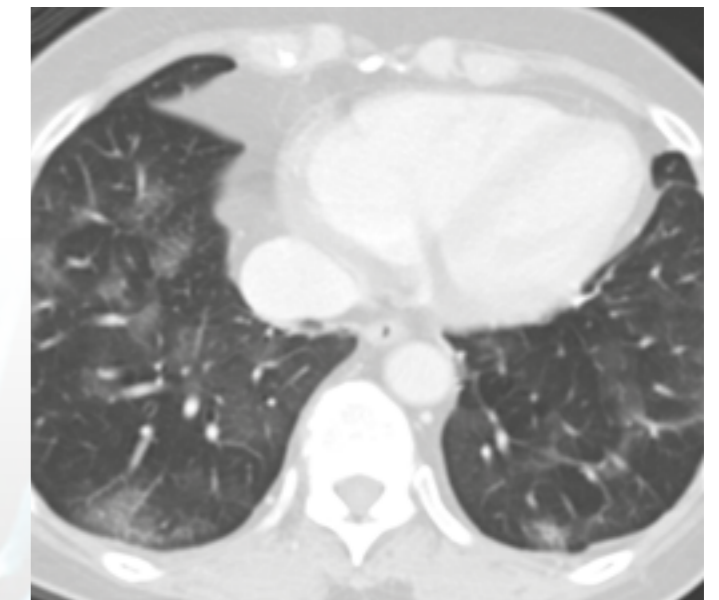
CT on Day 9 of symptom onset.
